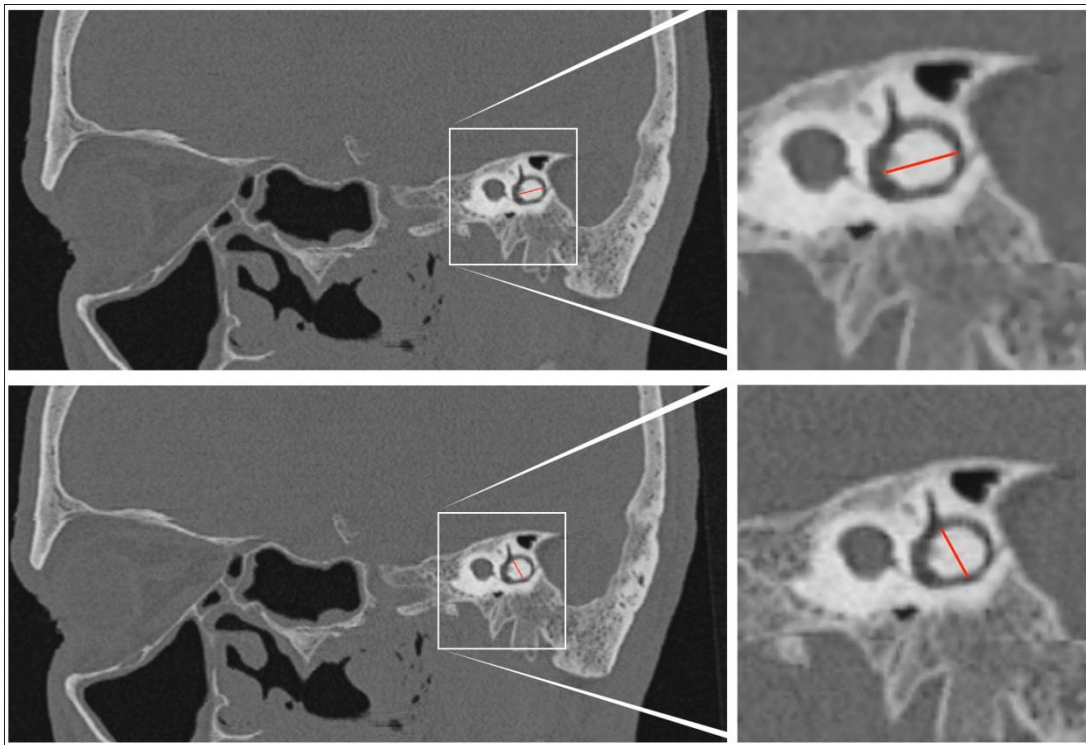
CT scan of petrous part of temporal bone, coronal oblique (Stenver) plane.
